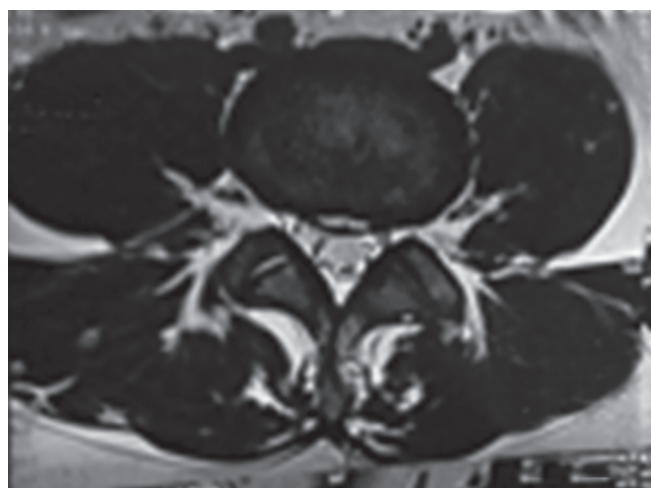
HIZ at L4-L5 disk level on T2-weighted MRI
